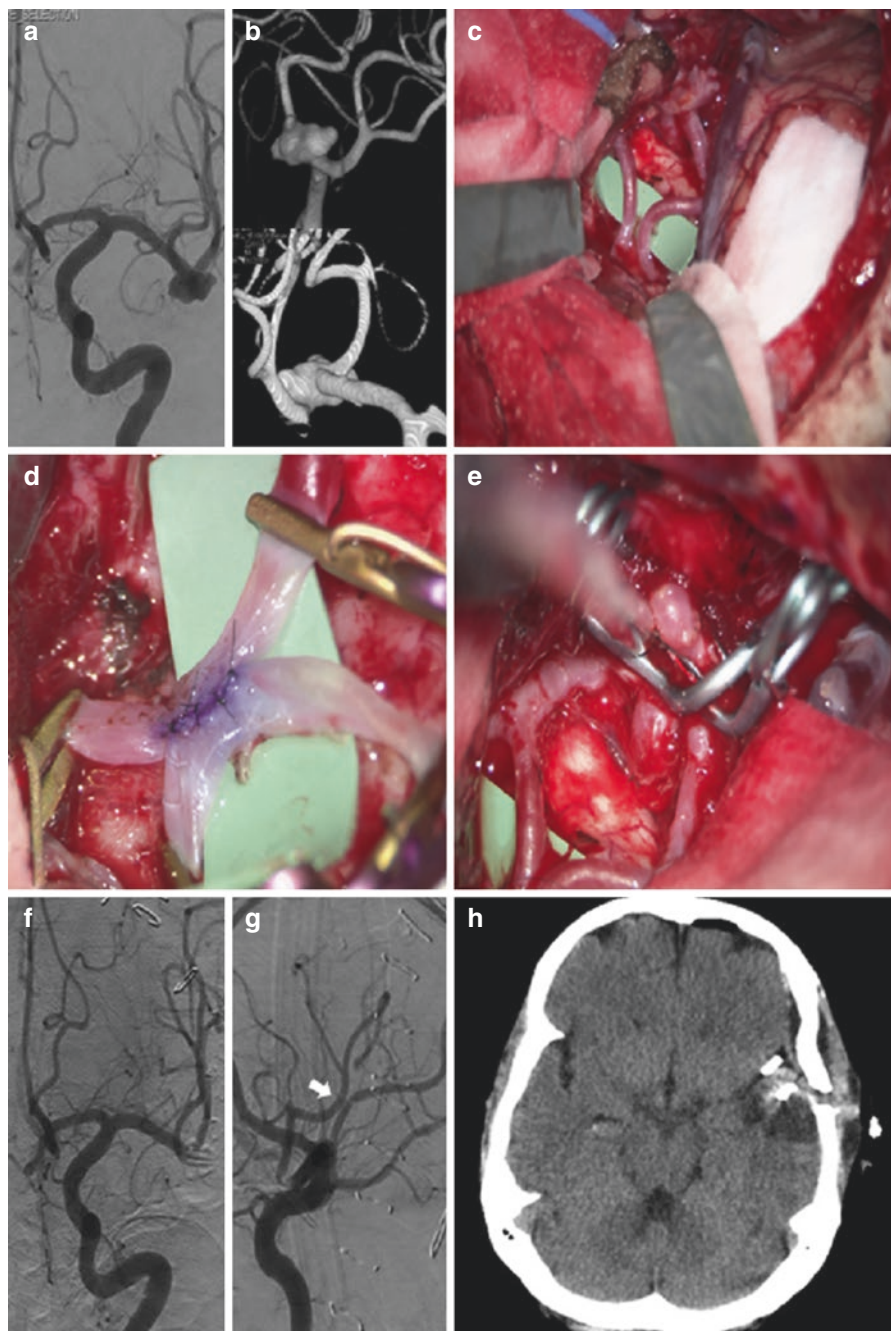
A 71-year-old diabetic and hypertensive man presented with mild aphasia secondary to a recent left MCA territory stroke. (a) Head CT shows a small left frontal infarct. (b) Left ICA angiogram reveals an 8-mm saccular aneurysm of the left MCA bifurcation with a 2-mm neck. There is an associated high-grade, flow-limiting stenosis of the M1 segment, which makes endovascular access particularly challenging and risky. Although the aneurysm's narrow neck makes it potentially clippable, the presence of significant atherosclerotic disease in the MCA puts the patient at imminent risk of perioperative stroke. We elected to proceed with surgical revascularization of the left MCA territory followed by clip deconstruction of the MCA bifurcation and aneurysm. (c) Left ECA angiogram demonstrates a well-sized parietal branch of the STA, which divides into two equally sizeable branches (white arrow). A "Y" bypass making use of these two donor vessels was thus planned. (d, e) Intraoperative microphotographs show a successful "Y" bypass to both M2 trunks (d, white arrows), followed by complete clip deconstruction of the MCA bifurcation and aneurysm (e). (f) Postoperative head CT. (g) Postoperative left ICA angiogram reveals successful occlusion of the MCA bifurcation and aneurysm, with preservation of the lenticulostriate arteries along the M1 segment. (h) Postoperative left ECA angiogram demonstrates a patent "Y" bypass supplied solely by the parietal branch of the STA, with robust opacification of the distal left MCA territory. (i) Preoperative NOVA qMRA shows markedly reduced flow (20–40 mL/min) in the left MCA territory. (j) Postoperative NOVA qMRA demonstrates high flow (85 mL/min) in the bypass graft
